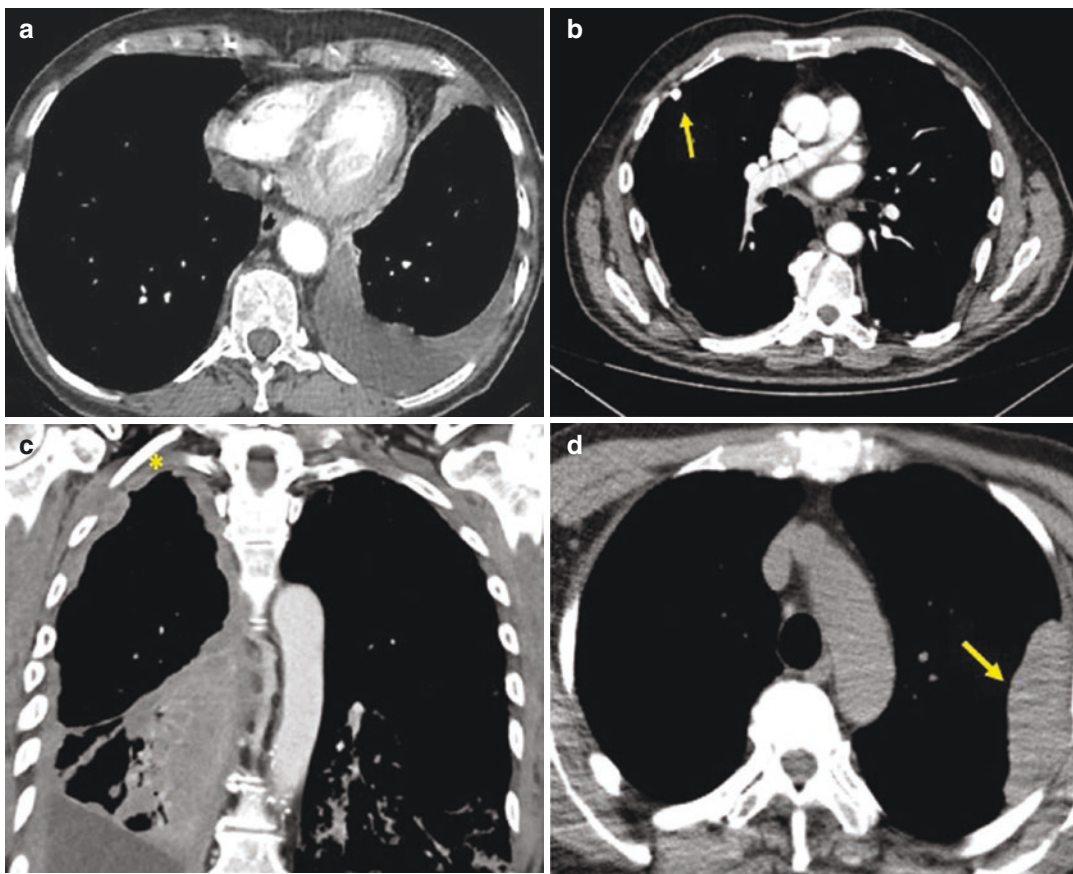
(a) CT shows left sided pleural effusion. (b) CT shows minimal pleural thickening and pleural plaques (arrow). (c) CT shows extensive involvement of parietal
